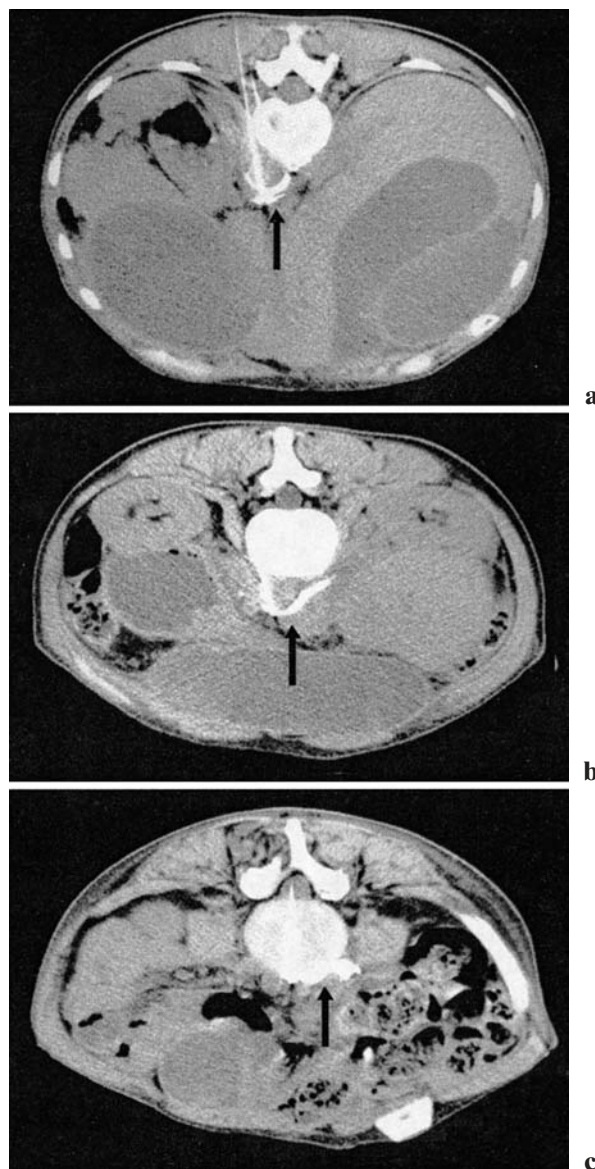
Computed tomography (CT) images at the level of T12–L1 for celiac plexus block (a transintervertebral disc approach), L2–L3 for inferior mesenteric plexus block (b transintervertebral disc approach), and L4–L5 for superior hypogastric plexus block (c transthecal approach) in a 62-year-old female patient with unresectable uterus cancer who suffered uncontrolled, incapacitating pain. Axial CT scans show appropriate placement of the needle tip and adequate spread of the contrast medium (*arrows*) around the target plexus
